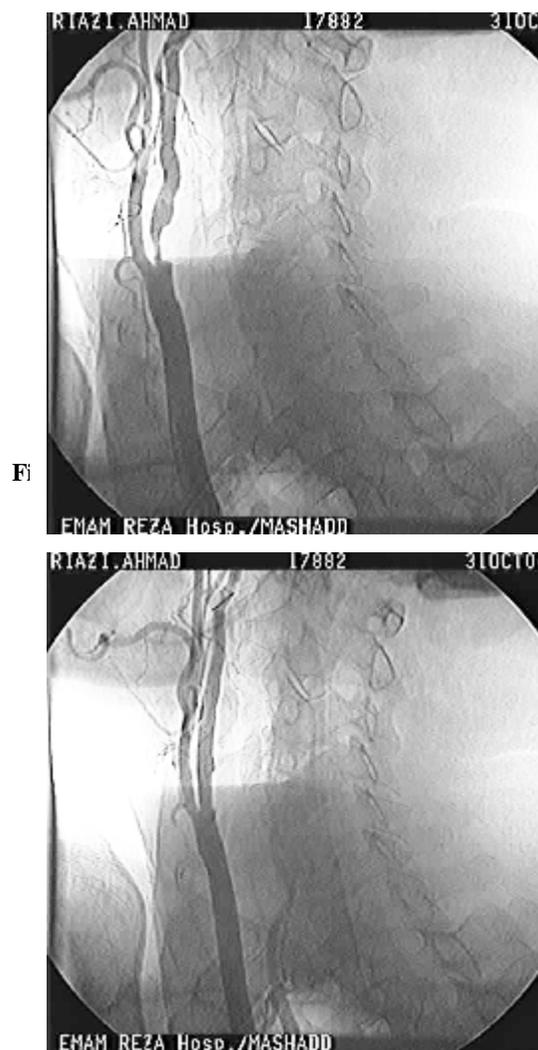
Angiograms demonstrating left internal carotid artery ostial stenosis in a 70-year-old man with history of hypertension, who presented with transient ischemic attack. Color Doppler ultrasonography revealed 70% stenosis in the left internal carotid artery (Fig 1-A). The final result after stenting (Fig. 1-B).
